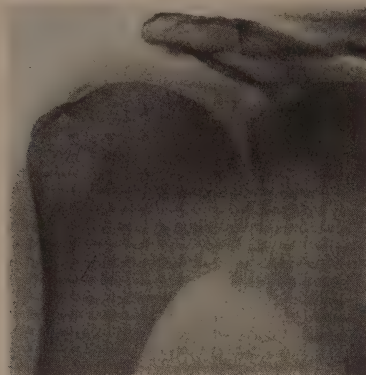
Subacromial bursitis (radiographic appearance).
